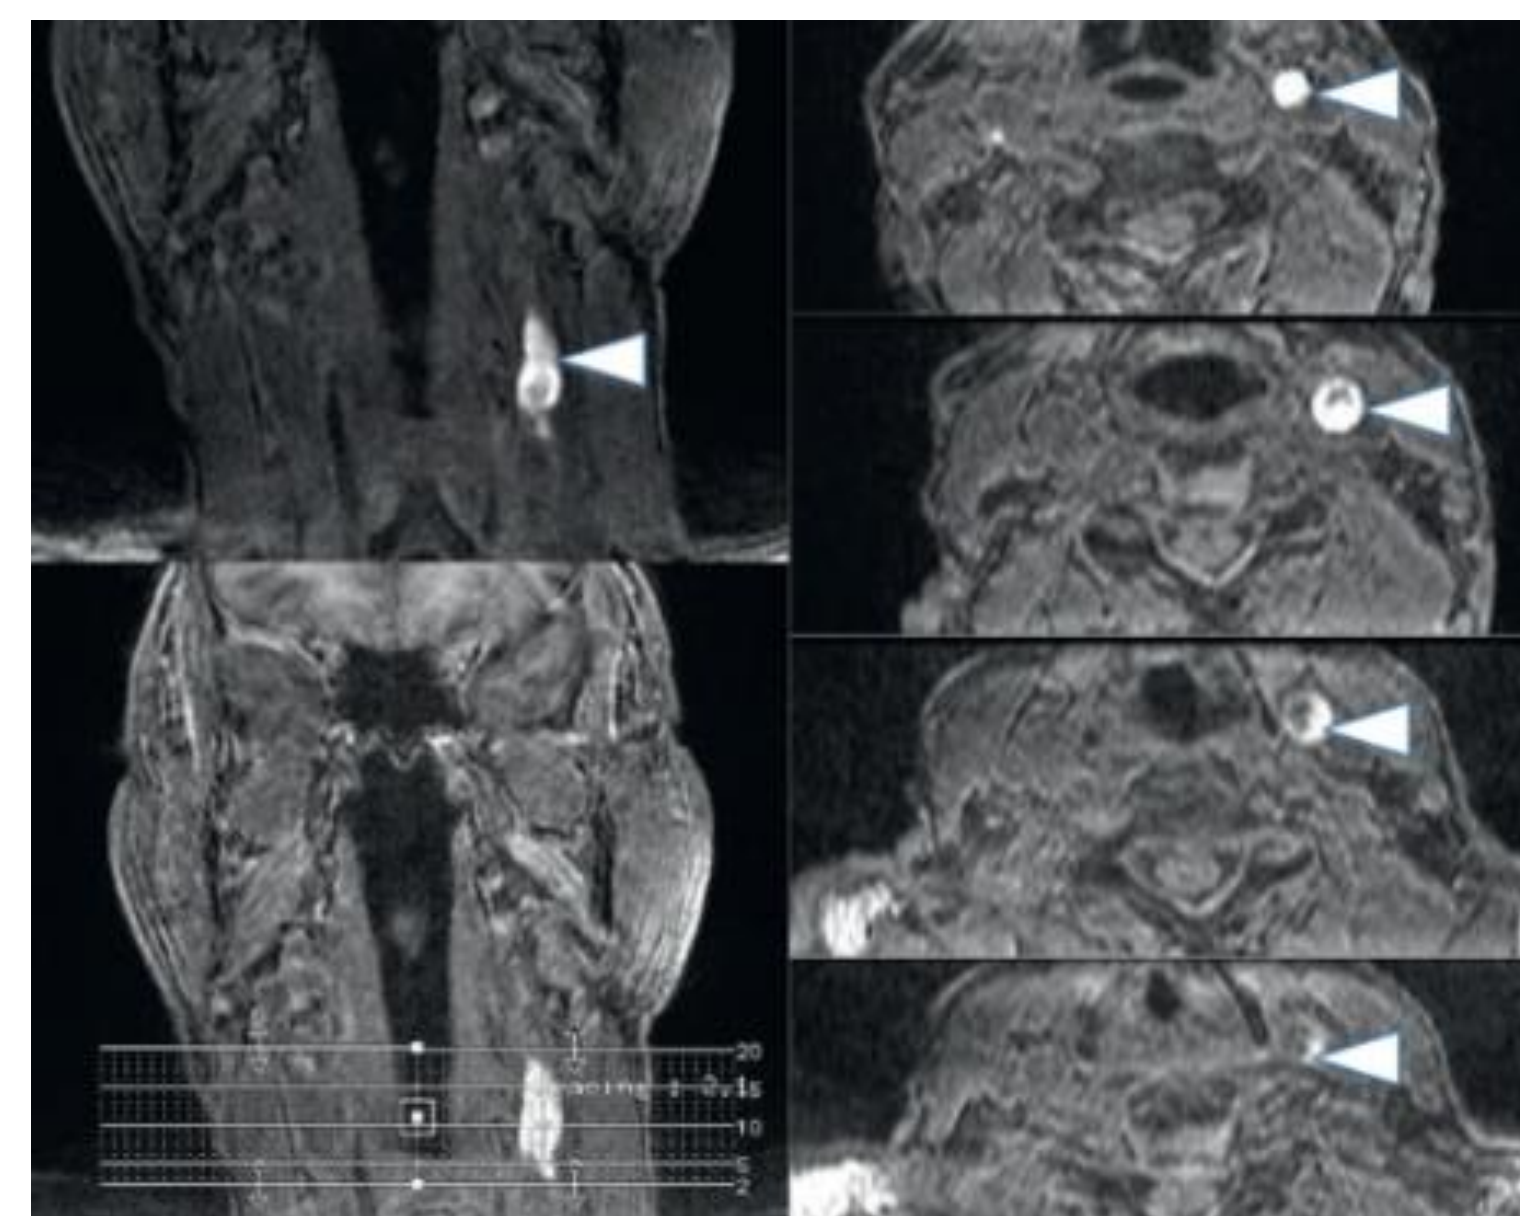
Baseline carotid stenosis was assessed using routine clinical imaging and confirmed with MRI.
